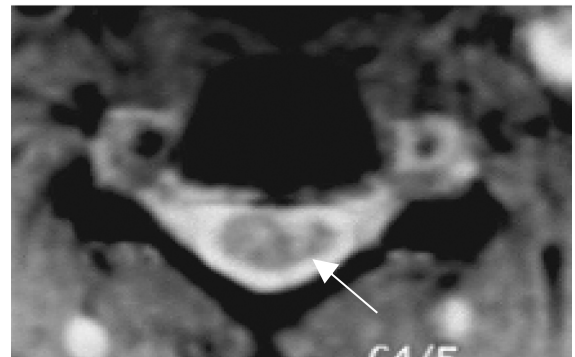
CT myelography shows cord atrophy at C5 to C7 levels with more severe changes on right side, ipsilateral to the atrophic limb.
